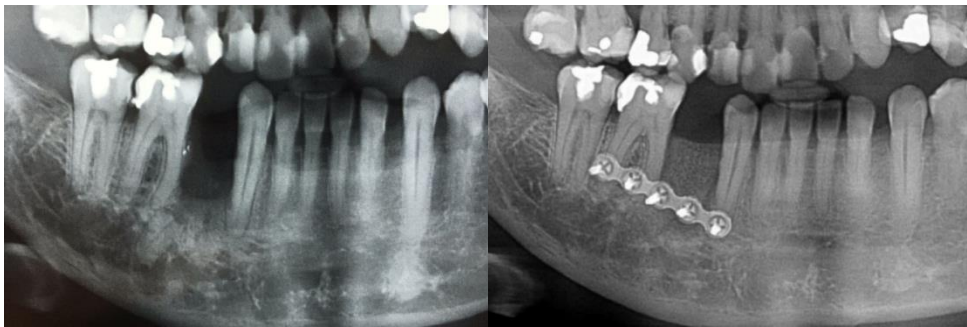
Comparison pre and post orthopantomogram radiograph.
